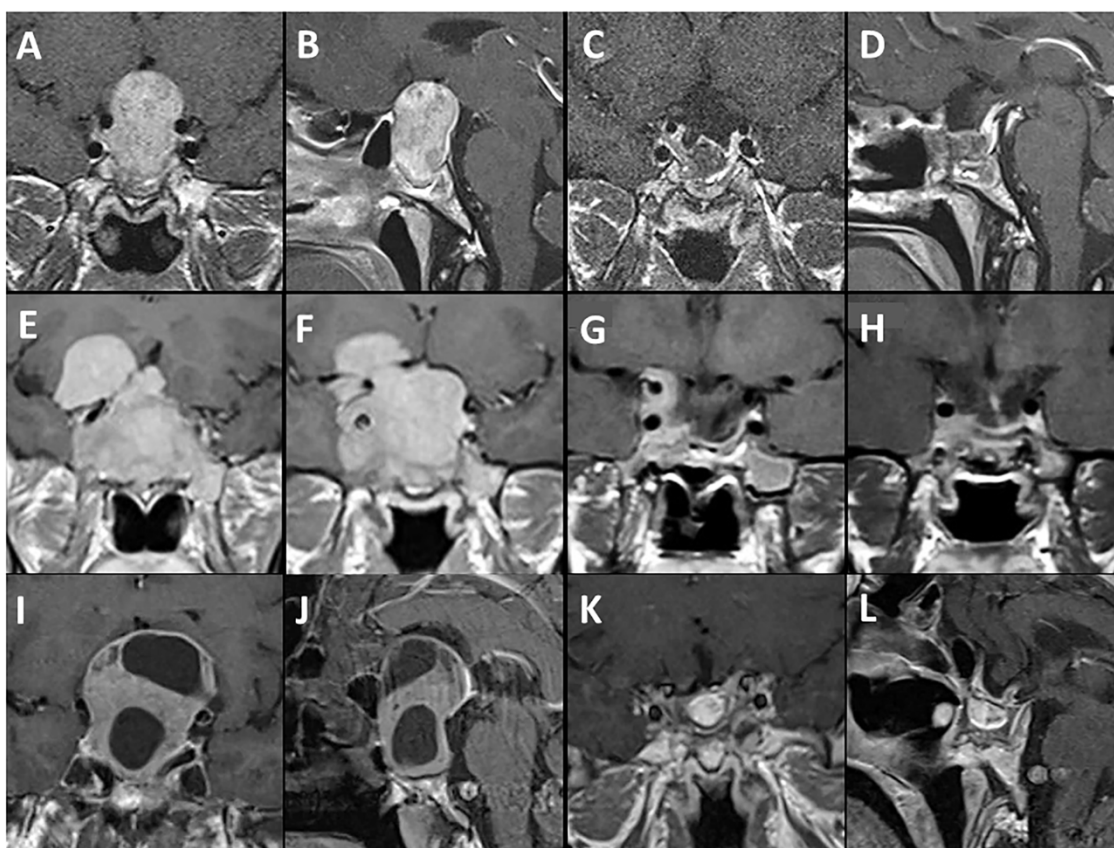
Preoperative (A and B) and postoperative (C and D) contrast enhanced T1-weighted MR images obtained in a 30 years old female patient who underwent gross total resection of a macroadenoma with suprasellar extension. Preoperative (E and F) and postoperative (G and H) contrast enhanced T1-weighted coronal plane MR images obtained in a 51 years old male patient who underwent resection of a giant adenoma with frontotemporal extension and right carotid artery encasement. Preoperative (I and J) and postoperative (K and L) contrast enhanced T1-weighted MR images obtained in a 47 years old male patient who underwent gross total resection of a giant adenoma with intracranial extension.
